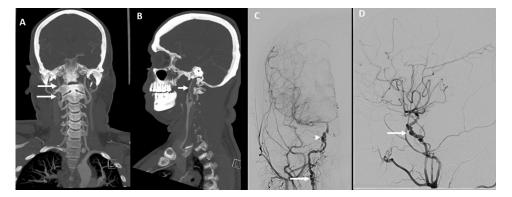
Figure I Vascular imaging in a young male patient with a history of right sided amaurosis fugax and right frontal ischemic stroke. Coronal (A) and sagittal (B) views of CT angiogram demonstrate moderate to severe stenosis of the entire right internal carotid artery cervical segment soon after its origin with significant irregularity and beading (white arrows). Anteroposterior (C) and lateral-oblique (D) views on digital subtraction angiogram of right internal carotid artery showed alternate stenosis and dilatation of the extracranial segment (white arrow (C)) and intracranial cavernous-supraclinoid segments (arrowhead (C); white arrow (D)), suggestive of "beading" typical of FMD.
